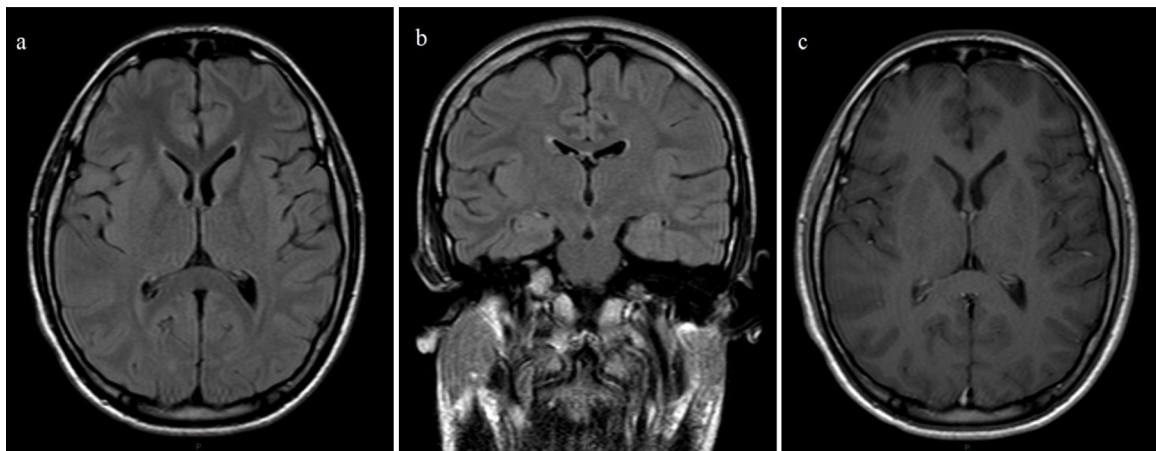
Brain MRI of the patient during the acute phase of the encephalitis (day 6 of fever onset). FLAIR axial and coronal sequences (a and b) and contrast T1 weighted sequence (c) showing no abnormalities.
